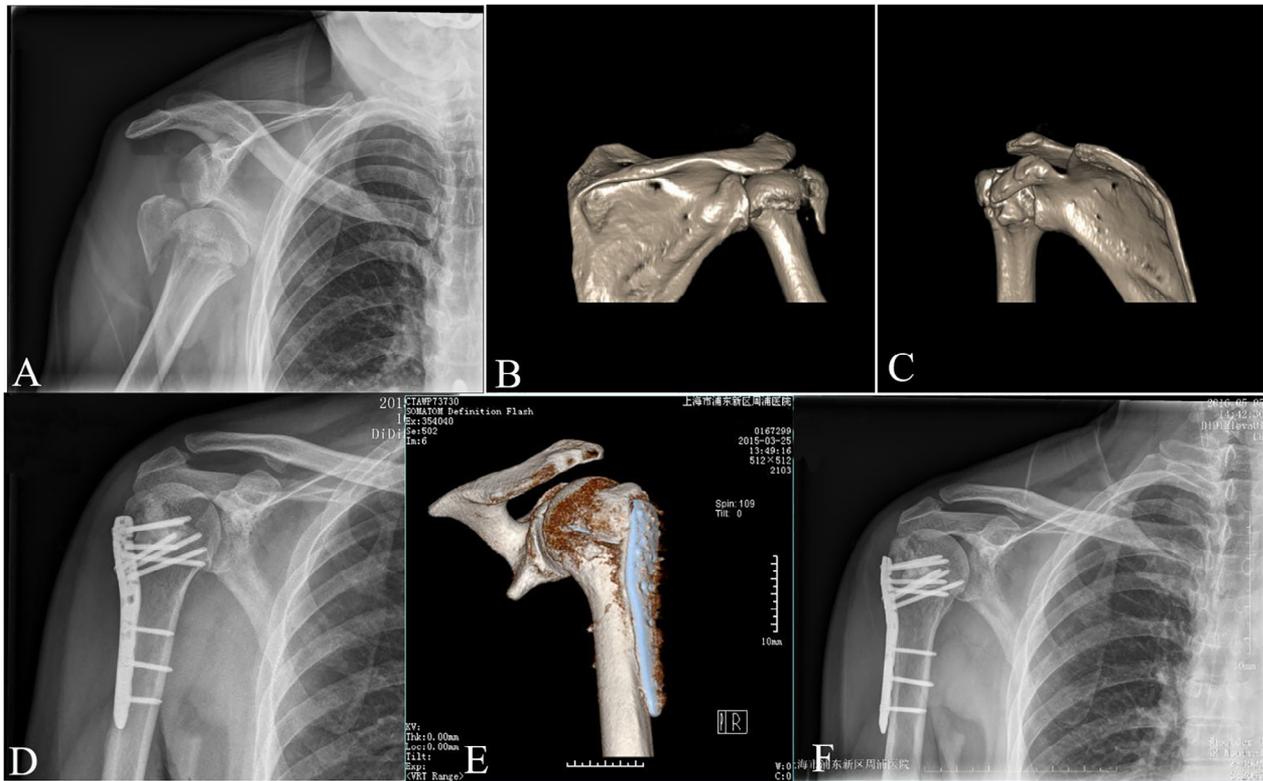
Imaging findings of a 58-year-old male patient with an ice cream anatomic neck fracture (ANF) and Constant-Murley score of 59 points at 3 months, 77 points at 12 months, and 73 points at the last follow-up visit. (A) Preoperative radiograph showing ANF with shoulder dislocation. (B) Preoperative computed tomography (CT) scan and 3-dimensional reconstruction, showing displacement of greater tuberosity. (C) Preoperative CT scan and 3-dimensional reconstruction, showing part of residual lesser tuberosity. Postoperative radiograph (D) and CT scan and 3-dimensional reconstruction (E) showing ANF fixed with proximal humeral locking plate and implanted artificial bone. (F) Radiograph showing osteosynthesis of ANF at 13 months postoperatively. There was no sign of osteonecrosis.
